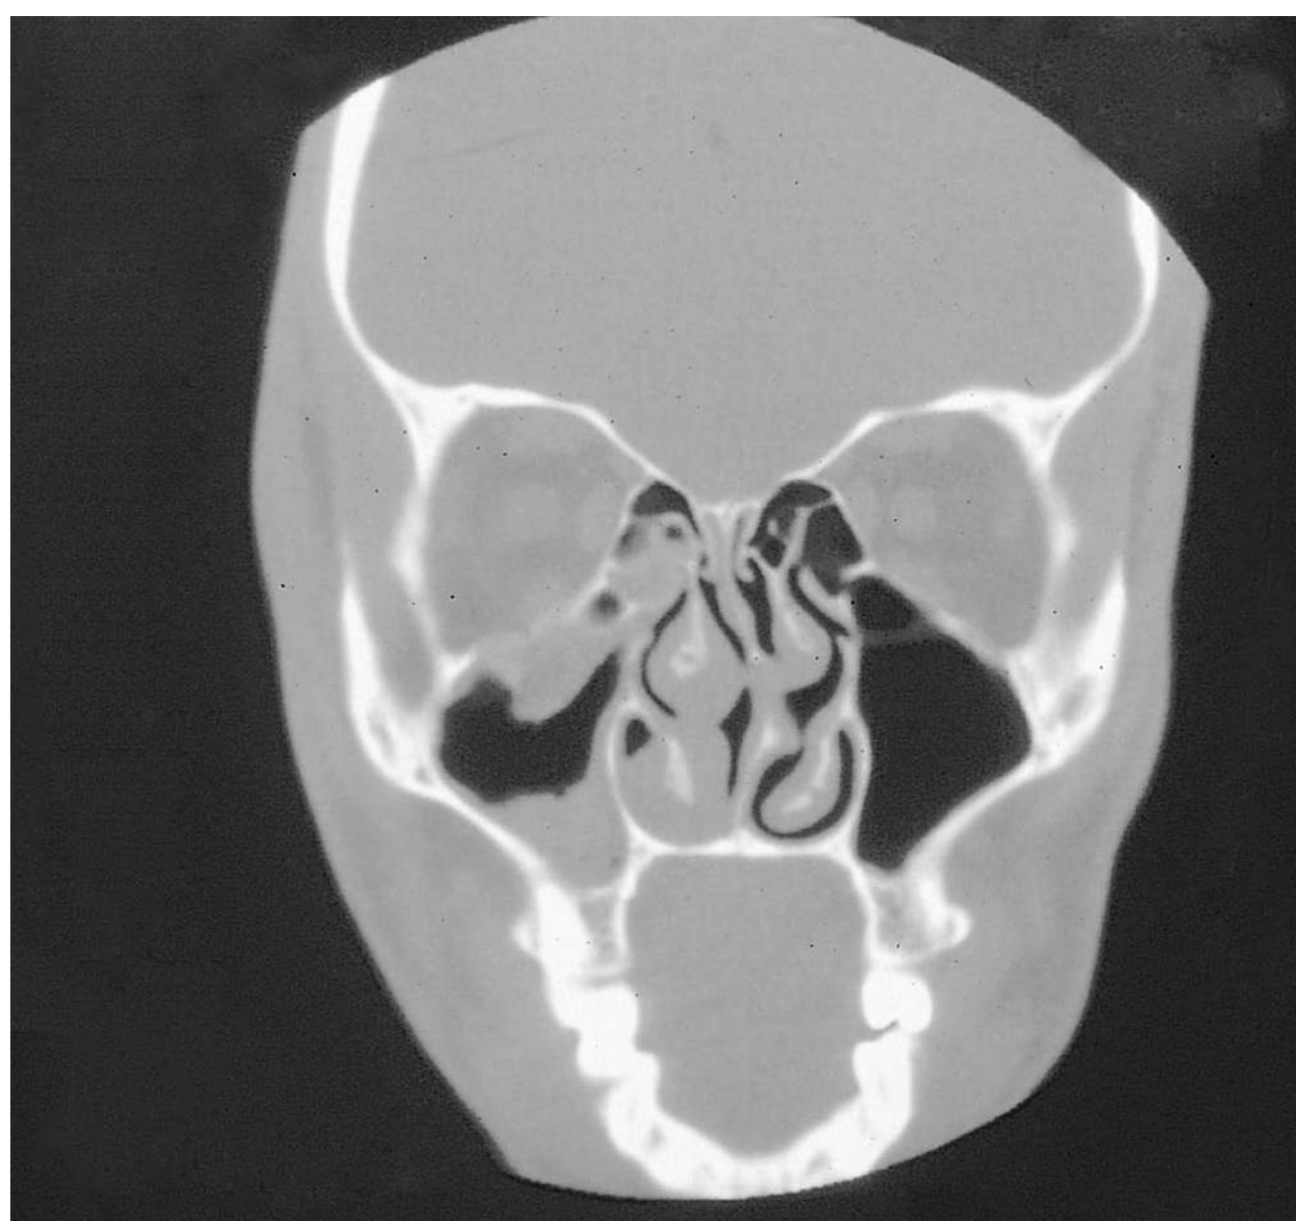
■ Orbital Floor Fracture with Entrapment. Coronal CT of the patient in Fig. 1.24 demonstrating the entrapped muscle extruding into the maxillary sinus. (Photo contributor: Lawrence B. Stack, MD.)
